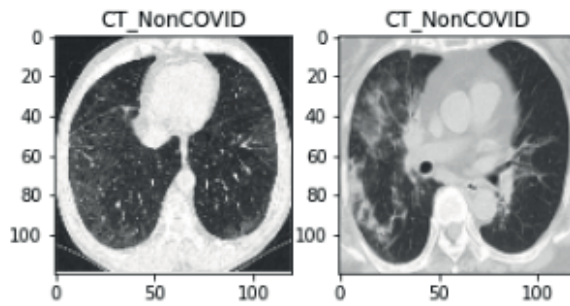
Lung CT scan normal
